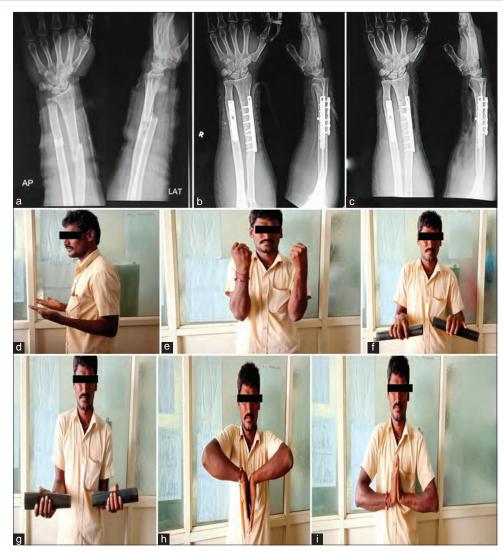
Clinical photographs. Case 1 – (a) Pre-operative X-ray, (b) Post-operative X-ray, (c) X-ray after 8 weeks, (d) Elbow 90° flexion, (e) complete elbow flexion, (f) Pronation, (g) Supination, (h) Wrist palmar flexion, (i) Wrist dorsiflexion
